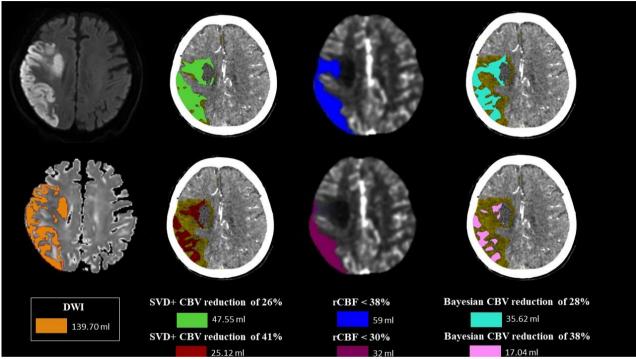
A 85 year-old woman with left hemispheric stroke. The initial NIHSS score was 12 and the time between CTP to MRI was 20 min. The infarct core volume was estimated 139.70 ml with DWI-ADC (orange color). The CTA demonstrates occlusion of the right M1 MCA. The infarct core volume was calculated 25.12 ml on SVD+ VITREA CBV reduction of 41% (red color), 47.55 ml on SVD+ VITREA CBV reduction of 26% (green color), 17.04 ml on BAYESIAN VITREA CBV reduction of 38% (pink color), 35.62 ml on BAYESIAN VITREA CBV reduction of 28% (turquoise color), 32 ml on RAPID rCBF < 30% (purple color), and 59 ml on RAPID rCBF < 38% ml (blue color).
